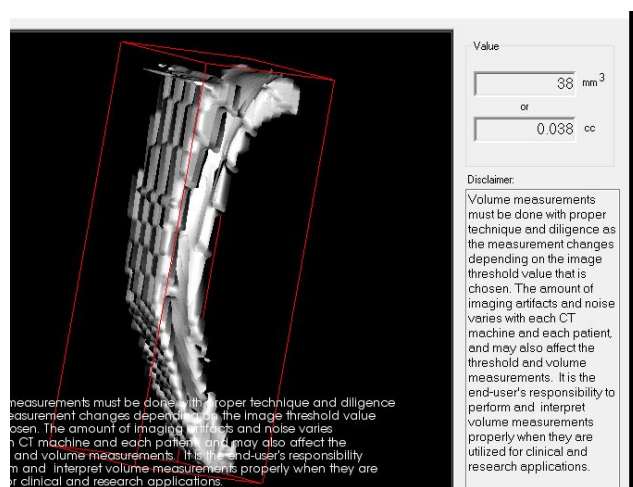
Post-operative scan calculating volume of the canal using CBCT
